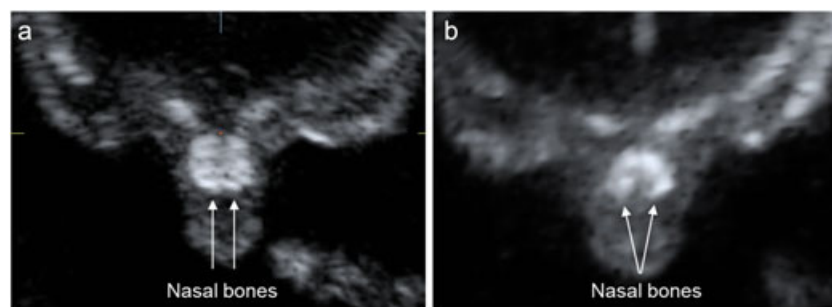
Ultrasound images from a chromosomally normal fetus (a) at 20 weeks demonstrating the two paired nasal bones fused on the midline in the coronal view and from a fetus with trisomy 21 (b) with divergent nasal bones (bifid)
